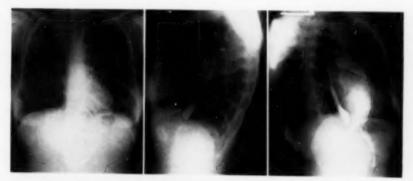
FIGURE 3B FIGURE 3C Figure 3: P-A, left lateral, and right anterior oblique chest roentgenogram in patient R. G. Minimal enlargement of the right ventricle, but not the left atrium, was demonstrated.
